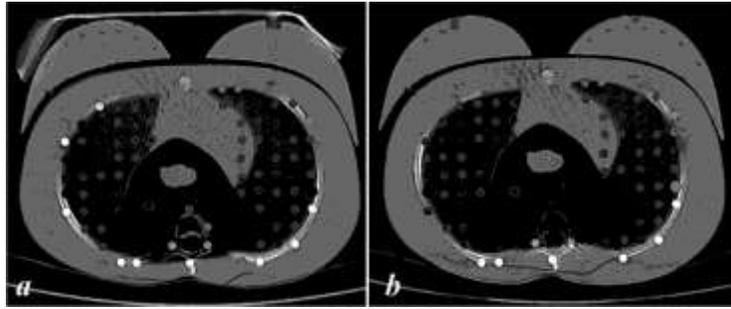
Axial thoracic CT images: (a) with and (b) without bismuth shielding.
